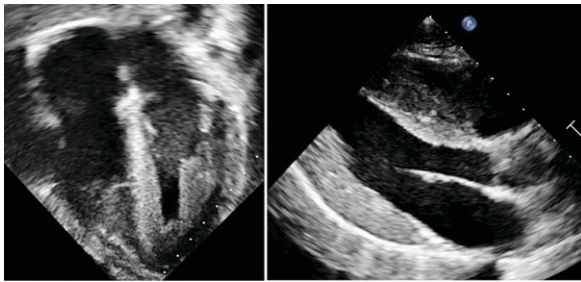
Echocardiograms showing left ventricular hypertrophy in a teenager with hypertrophic cardiomyopathy.
